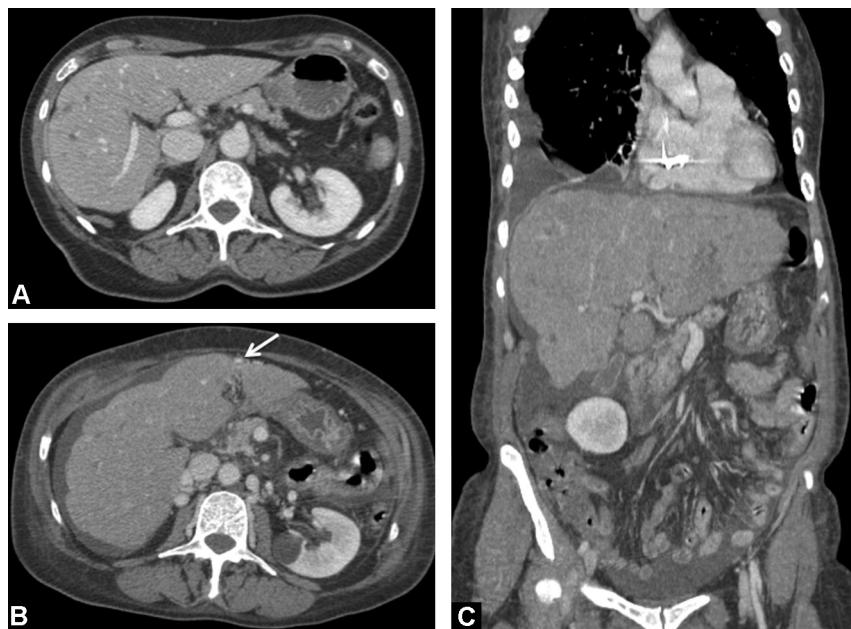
Case #3, CT scans. A. A 59-year-old patient with liver metastases (black arrows) secondary to an invasive ductal carcinoma of the breast. B and C. Two months later, CT scan revealed large capsular retraction associated with moderate ascites and patent para-umbilical vein (white arrow). The patient died of hepatic failure 3 weeks later.
